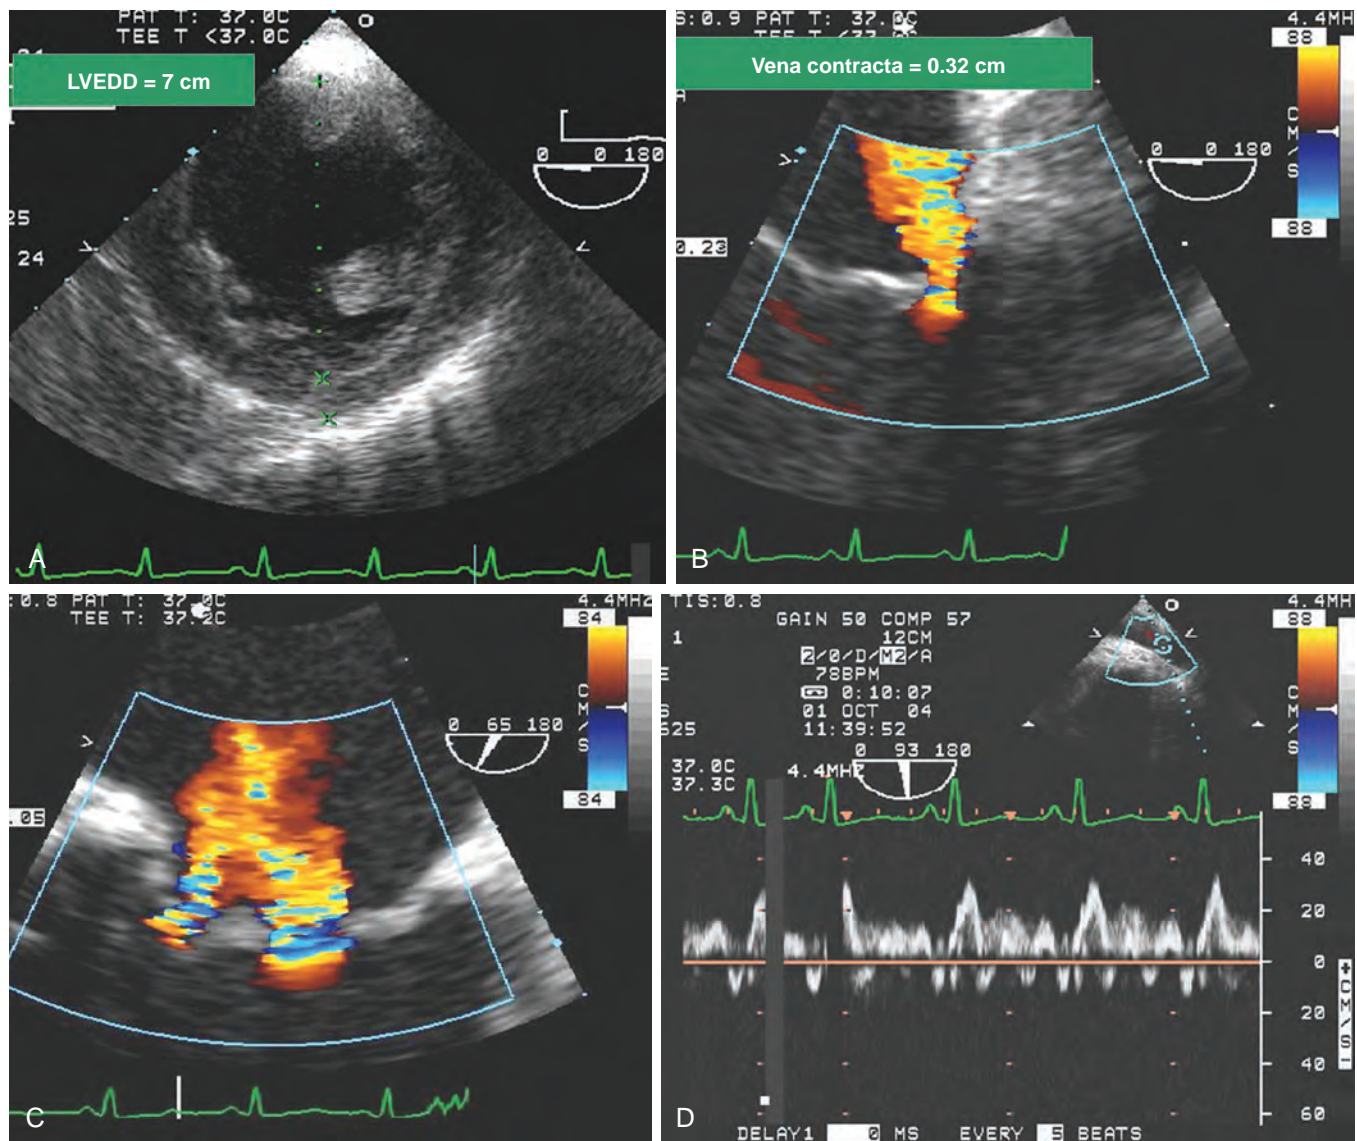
Evaluation of mitral regurgitation (MR) in a patient undergoing coronary artery bypass grafting. A 63-year-old man was scheduled to undergo off-pump coronary artery revascularization. The patient had a history of progressive congestive heart failure without evidence of acute pulmonary edema. The physical examination was significant for a diffuse, laterally displaced point of maximum impulse and a systolic murmur at the apex that radiated to the axilla. (A) The patient received an intraoperative transesophageal echocardiography examination to evaluate the severity of MR. The left ventricle was significantly dilated with a left ventricular end-diastolic dimension (LVEDD) of 7 cm and had depressed systolic function with an estimated ejection fraction of 40%. (B) The MR was characterized by color-flow Doppler imaging to be a central jet of mild-to-moderate severity. The grading of MR was based on the area of the regurgitant jet and the vena contracta viewed in a long axis view. The pathogenesis of MR was believed to be functional and resulted from restricted leaflet mobility caused by the dilated left ventricle. (C) The coaptation of the anterior and posterior leaflets was below the valve plane. (D) The absence of reversal of pulmonary vein blood flow measured in the left lower pulmonary vein supported the assessment of moderate MR. Because the annulus was not significantly dilated (the minor axis measured 2.97 cm) and the MR was graded as only mild to moderate, the surgeon proceeded with the initial plan of off-pump coronary artery bypass grafting. The MR decreased immediately after revascularization, and the patient's symptoms were expected to improve further with afterload reduction.
